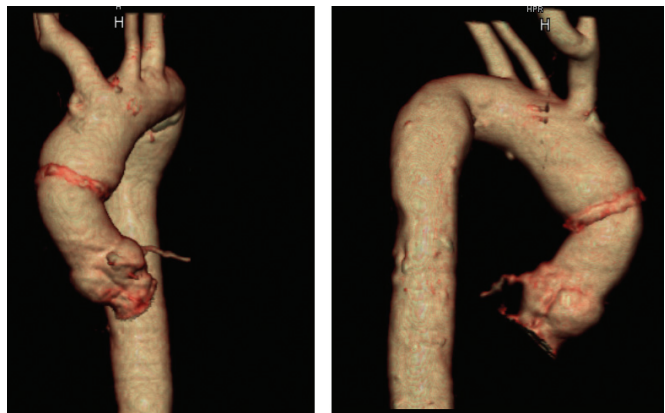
Multidetector-row computed tomography. Volume rendering images demonstrating a normal anatomy restoration of the aortic root after reimplantation technique using the Valsalva graft (Vascutek, Renfrewshire, Scotland, UK).
